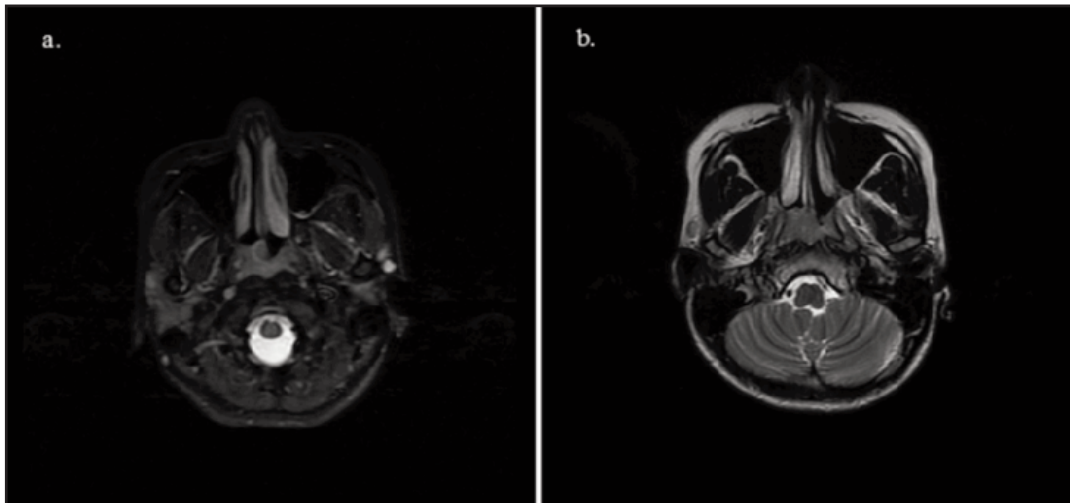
(a) Axial MRI showing nasopharyngeal carcinoma at the right Fossa of Rosenmuller, at diagnosis. (b) Axial MRI showing nasopharyngeal carcinoma 3 months.
